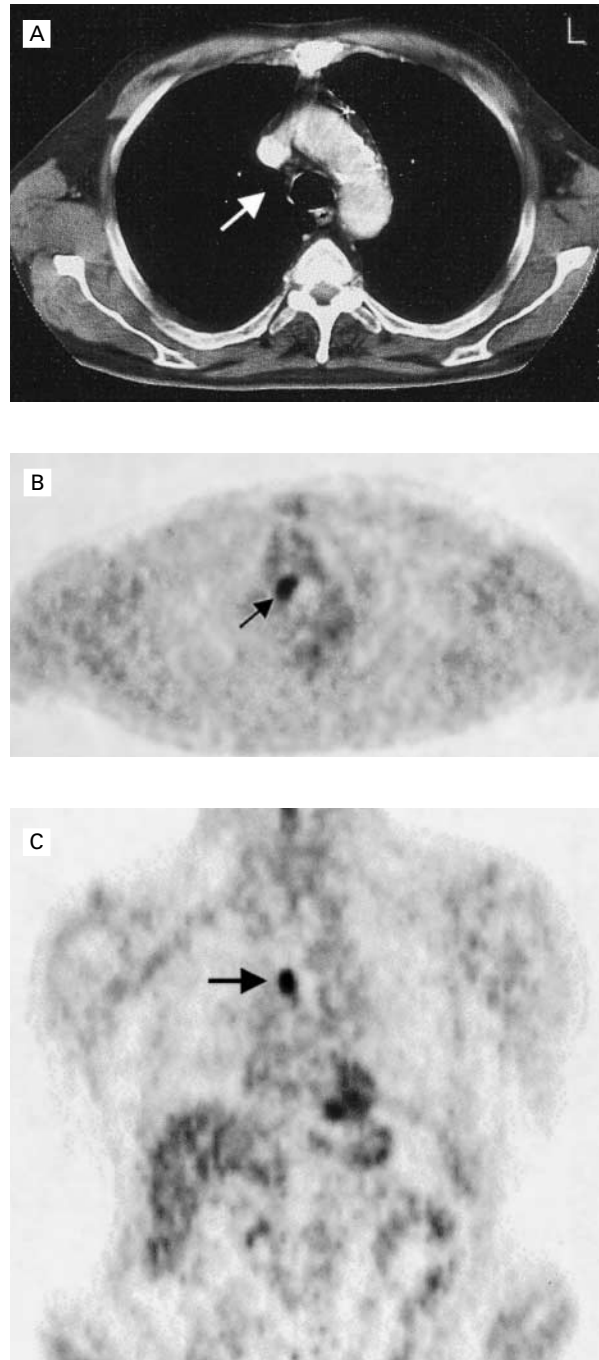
CT and PET Findings in a Patient with Squamous-Cell Carcinoma of the Right Lung.
